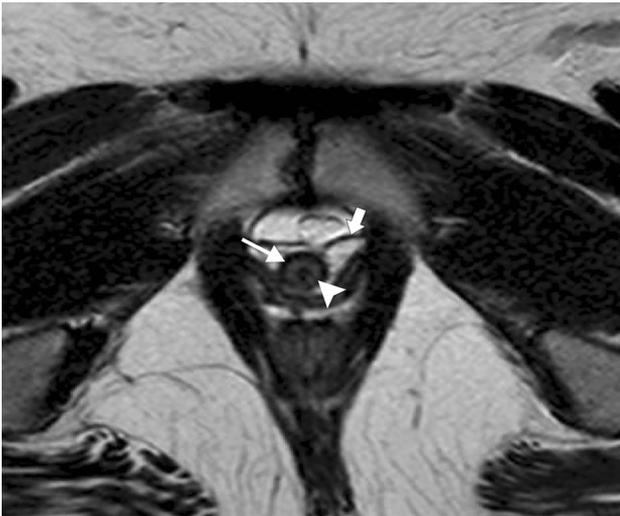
Normal zonal anatomy of the female urethra on MRI. Axial T2-weighted image demonstrates the target appearance of the normal female urethra. The inner mucosal layer is slightly hypointense on T2WI, the vascularized connective tissue of the submucosa is hyperintense (arrowhead), and the outer muscular layer is hypointense (long arrow). Periurethral ligaments (short arrow) can also be seen
